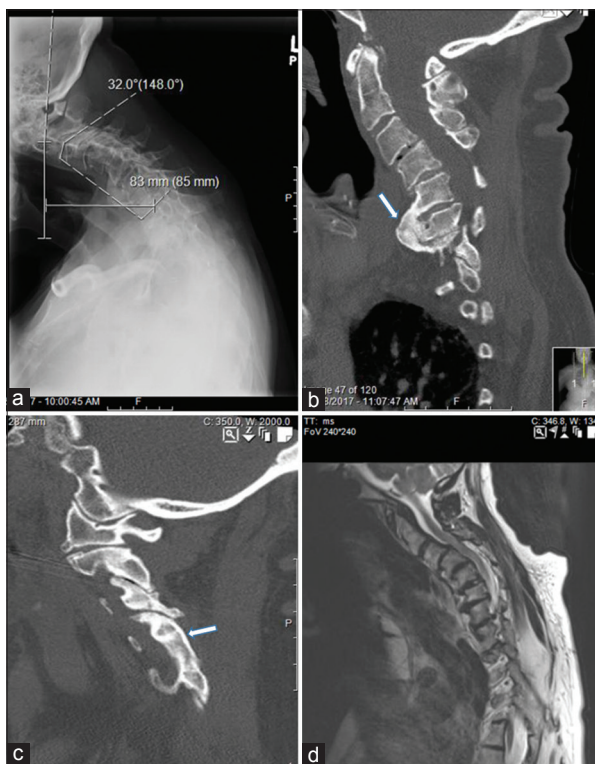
Upright lateral cervical spine X-ray (a) sagittal computed tomography (b and c) and sagittal T2-weighted magnetic resonance imaging (d) demonstrating fixed cervical kyphotic deformity with presence of ankyloses both anteriorly and posteriorly. (arrows in image b and c) and cervical spinal cord compression (d) There is presence of 32° of cervical kyphosis between C2–C7 and about 8 cm C2–C7 sagittal vertical axis
